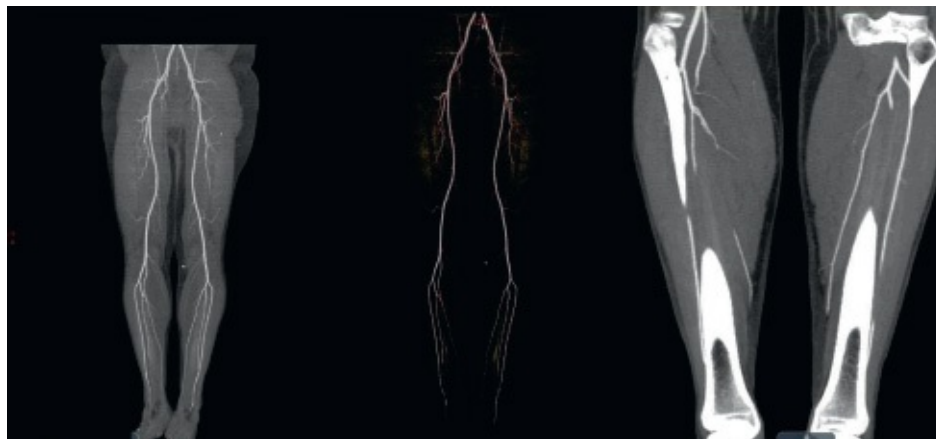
• CTA shows normal angiogram of bilateral thighs and three vessel runoff of the legs.
